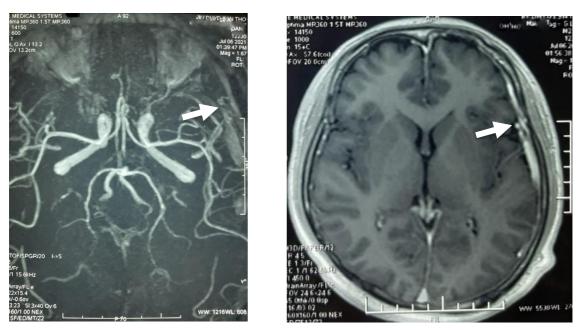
Axial TOF3D and Axial T1W CE MRI: dural arteriovenous fistula (arrow) Intracranial dural arteriovenous fistula is characterized by pathological anastomoses between meningeal arteries and dural venous sinuses, meningeal veins, or cortical veins. The disease usually has diversity of clinical symptoms such as headache, tinnitus, vision loss, bulge of the eyes. It can cause complications such as inracranial hemorrhage, intracranial hypertension, which can be life-threatening. However clinically, this patient had only extremely subtle symptom of headache which was explained by the hematoma. The condition was resolved under interventional endovascular embolization. The endovascular intervention was conducted under the digital subtraction angiography (DSA) system for about 2 hours to check and embolize the fistula with Lipiodol. The interventional results were completely blocked of the feeding branches, the middle meningeal arteries at the sites of the fistula.
